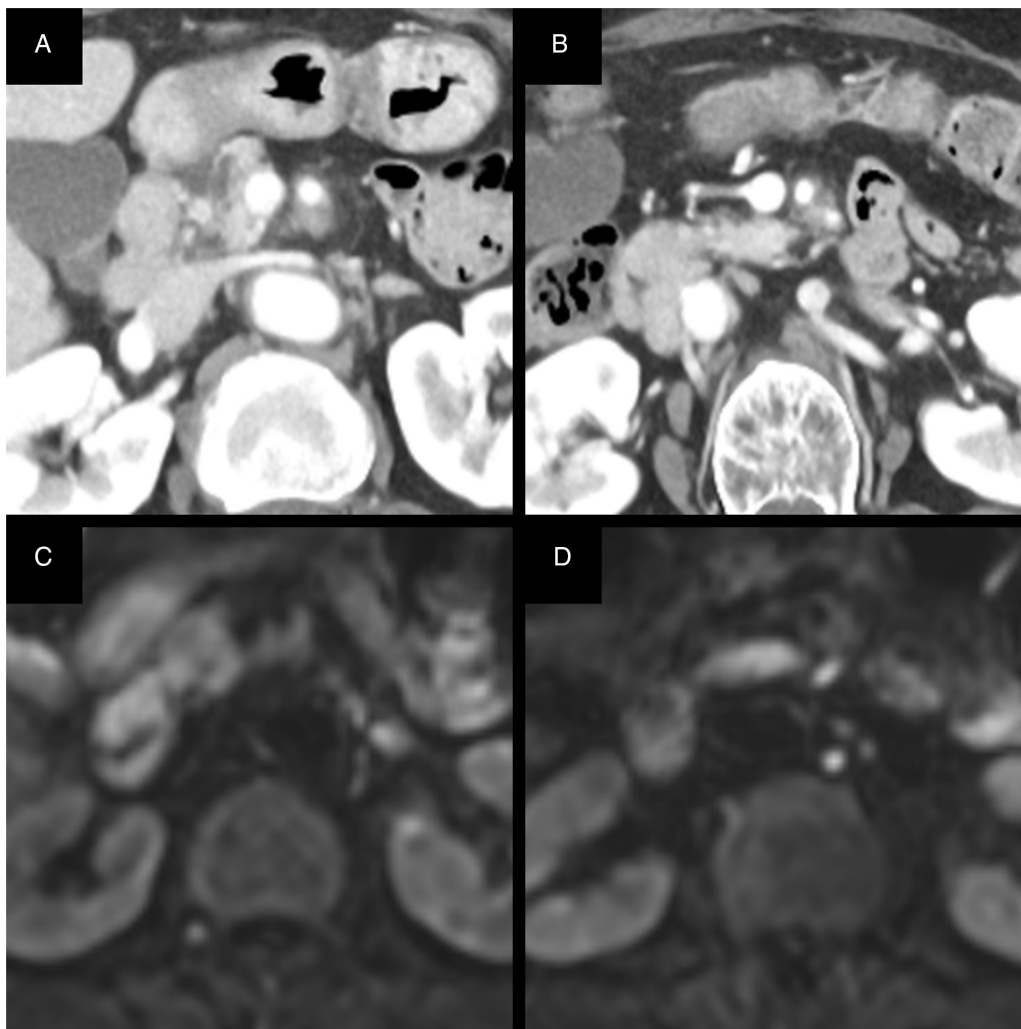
Enlarged (magnified) views focusing on the SMA region. (A and B) Baseline contrast-enhanced computed tomography images demonstrate peri-vascular soft-tissue encasement around the SMA, raising radiological suspicion for perineural/perivascular extension. (C and D) Corresponding magnetic resonance imaging demonstrates a peri-vascular soft-tissue lesion around the SMA, supporting radiological suspicion of SMA-related perineural/perivascular involvement. SMA, superior mesenteric artery.
